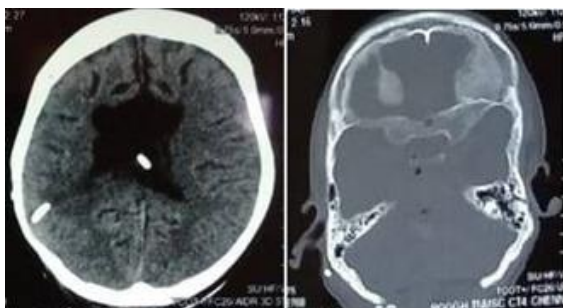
Post-operative CT brain of the patient mentioned in case V, showing the right (previously inserted) and left VP shunts in situ. Sub-occipital craniectomy defect can be seen in the picture on the right
